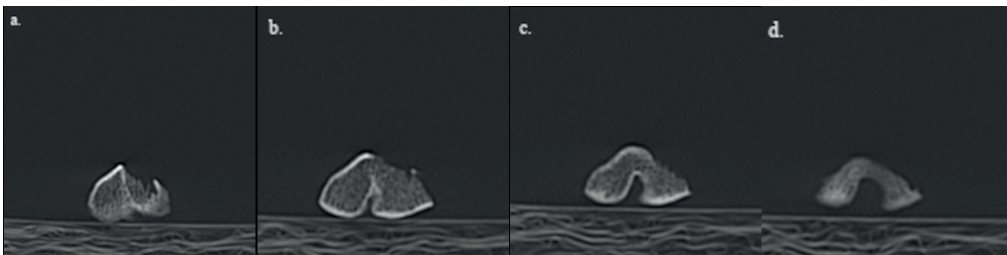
Series of CT scan images of BMC (a-d), displaying a series of cross sections through the condyle for the visualization of internal bone structure
